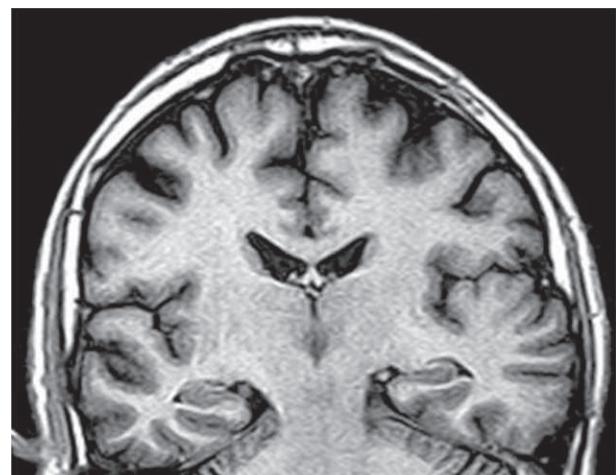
Coronal T1-inversion recovery MRI showing enlargement of left temporal lobe in a patient with familial TLE with auditory auras. Observe also an abnormal pattern of the first and second temporal sulci as compared to the right side.
